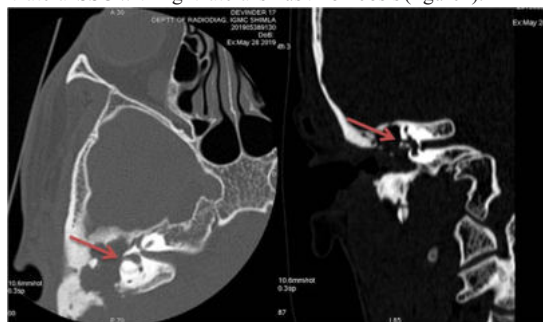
HRCT temporal bone showing labyrinthine fistula in (a)axial (b)coronal section
